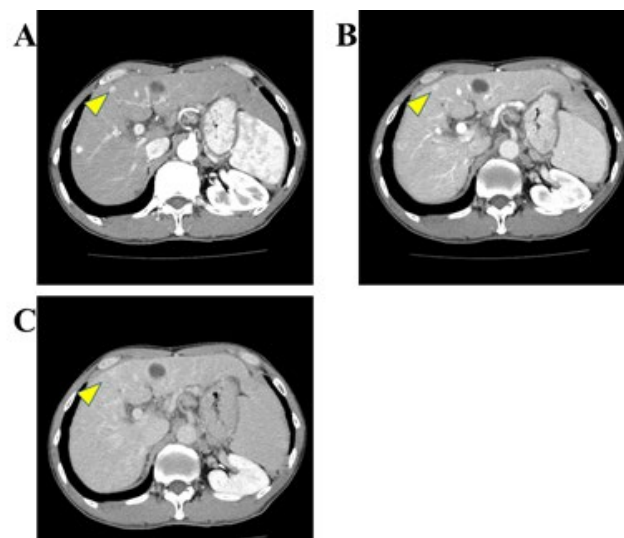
(A) Dynamic CT images show a faint lesion in the early phase (yellow arrowhead). (B) Mosaic pattern containing both enhancing and non-enhancing areas in the portal phase (yellow arrowhead). (C) Faded and delayed contrast-enhancing areas in the late phase (yellow arrowhead). CT, computed tomography
